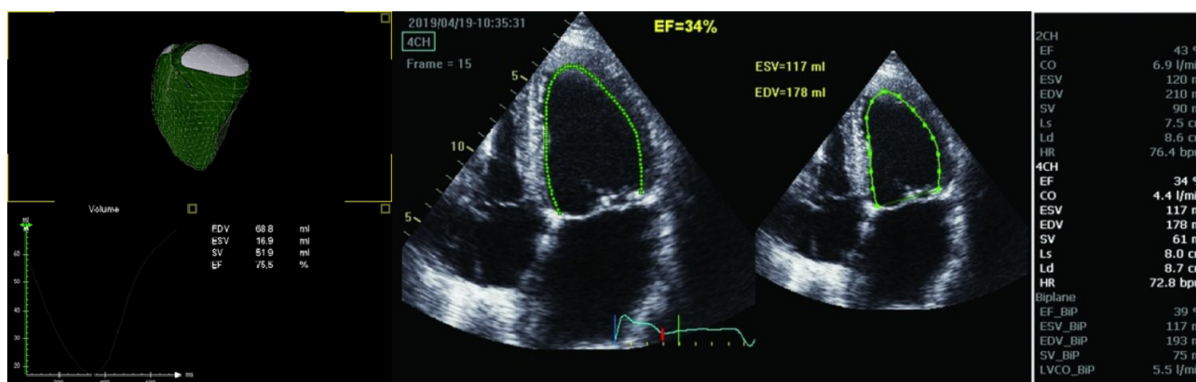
Three-dimensional echocardiographic reconstruction of the delineation of right ventricular ejection fraction. The endocardial border is traced throughout the cardiac cycle using speckle tracking, and the software automatically locates end-systolic and end-diastolic frames. Example of a four-dimensional echocardiographic reconstruction of the delineation of the right ventricle seen from the septal side (end-diastolic volume 68.8 mL, end-systolic volume 16.9 mL, and ejection fraction 75.5%). The mesh is the right ventricle at end-diastole, in green at end-systole. The pulmonary valve is shown in white on the upper left side, the tricuspid valve is shown on the upper right side, and the right ventricular apex toward the bottom.
